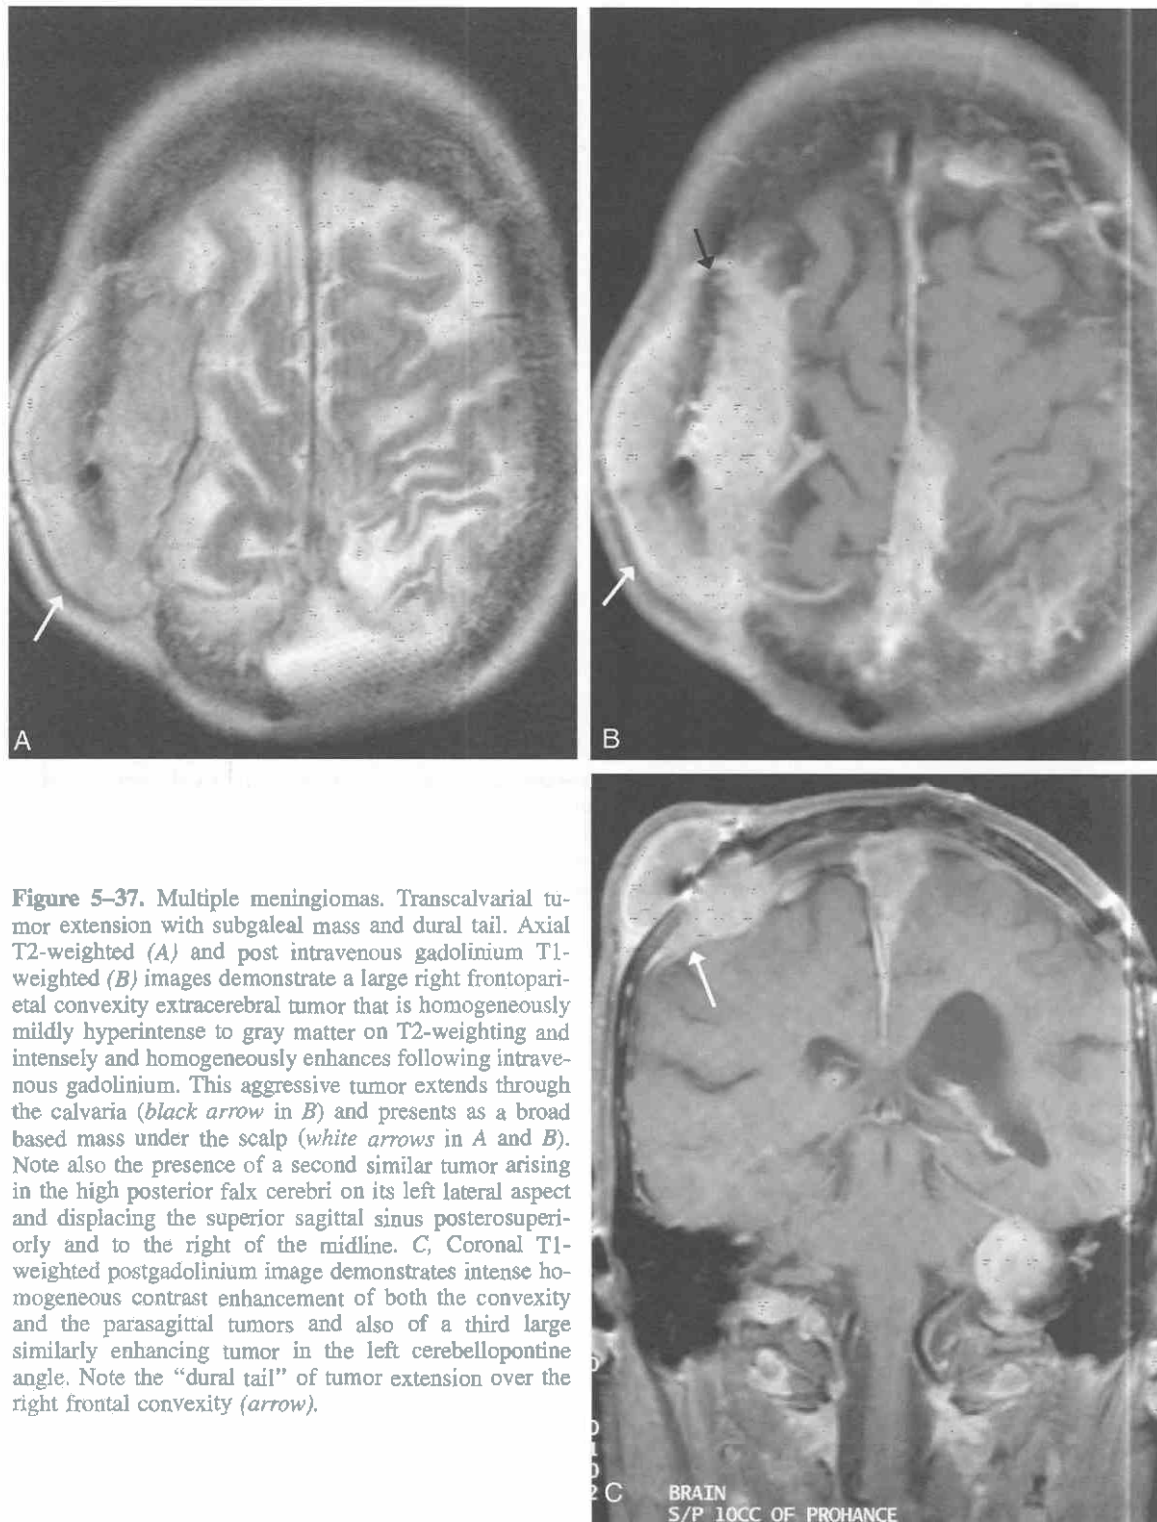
Multiple meningiomas. Transcalvarial tumor extension with subgaleal mass and dural tail. Axial T2-weighted (A) and post intravenous gadolinium T1-weighted (B) images demonstrate a large right frontoparietal convexity extracerebral tumor that is homogeneously mildly hyperintense to gray matter on T2-weighting and intensely and homogeneously enhances following intravenous gadolinium. This aggressive tumor extends through the calvaria (black arrow in B) and presents as a broad based mass under the scalp (white arrows in A and B). Note also the presence of a second similar tumor arising in the high posterior falx cerebri on its left lateral aspect and displacing the superior sagittal sinus posterosuperiorly and to the right of the midline. C, Coronal T1-weighted postgadolinium image demonstrates intense homogeneous contrast enhancement of both the convexity and the parasagittal tumors and also of a third large similarly enhancing tumor in the left cerebellopontine angle. Note the “dural tail” of tumor extension over the right frontal convexity (arrow).
